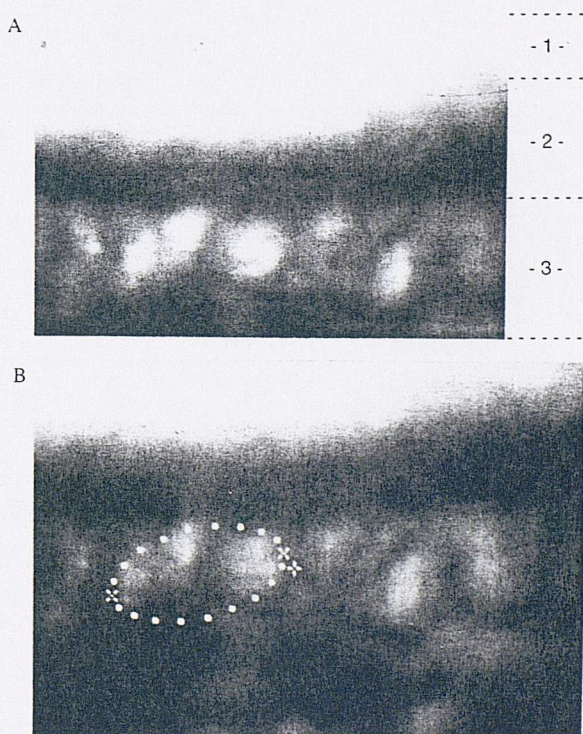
A : Imagerie à haute résolution de la paroi artérielle montrant les unités « glomérule-like » des vasa vasorum, régulièrement espacées le long de la paroi artérielle. 1 : lumière artérielle (en blanc) ; 2 : complexe intima-média ; 3 : couche adventitielle-périadventitielle contenant les unités « glomérule-like » des vasa vasorum. B : Dans la figure du bas, trois unités sont montrées, leurs vaisseaux individuels étant visualisés par le Doppler de puissance.
